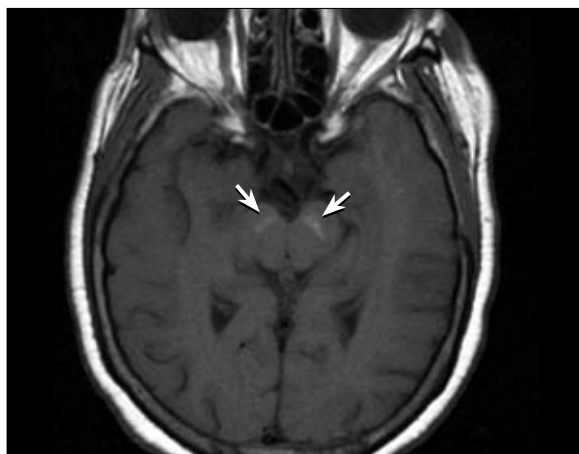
Axial spin-echo T1-weighted MR image demonstrates hyperintense signal in a location analogous with the substantia nigra on day 6.
